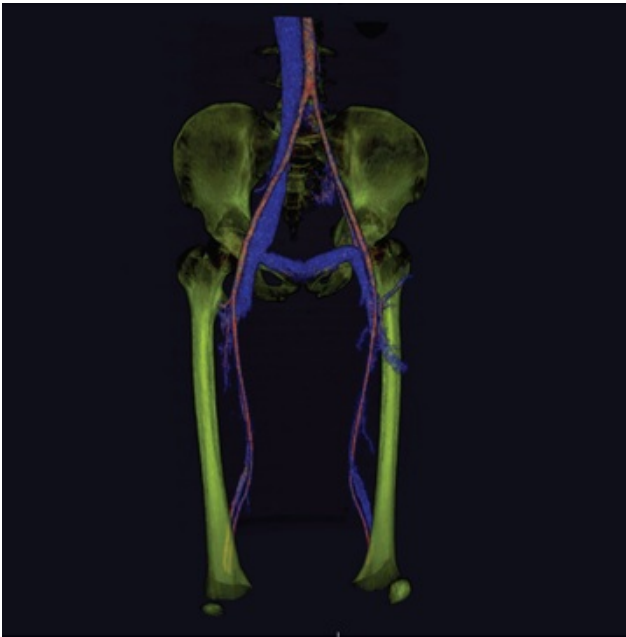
3-D MRI reconstruction of a 26-year-old male demonstrates aplasia of the left common iliac vein. Evaluation of patency and anatomical variations of the deep venous system is vital in all KTS patients prior to establishing a definite treatment plan, due to relatively high incidence of deep venous system anomalies.
